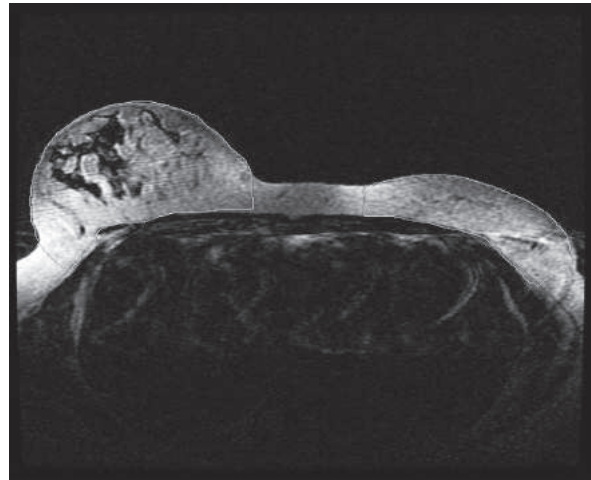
Volume measurement was performed on Advantage Workstation version 4.2 (GE Healthcare, Milwaukee, Wisconsin). The margin of right breast and adjacent subcutaneous tissue was defined by 3D tools manually slice by slice on a series of axial images, and the volume was calculated by volume tool. The final volume difference was then obtained by subtraction of left breast (472 cm^3) from the right breast (827 cm^3). The MRI-estimated volume was ($827 - 472 = 355$) around 355 cm^3 .
